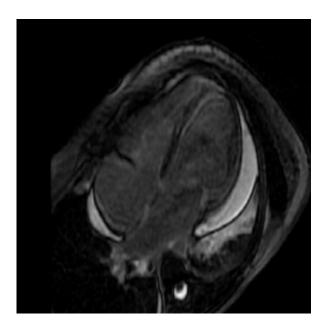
Cardiovascular magnetic resonance imaging shows lateral, mid-distal septal, and apical wall subendocardial scarring with a pericardial effusion.
